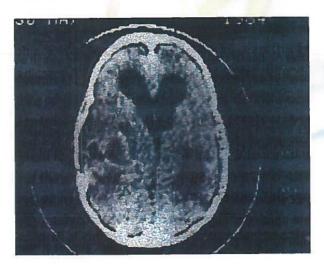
(a) CT Scan. Glioma left hemisphere, April 1978; Fig. 11 (b) CT Scan. Post operative November 1980
